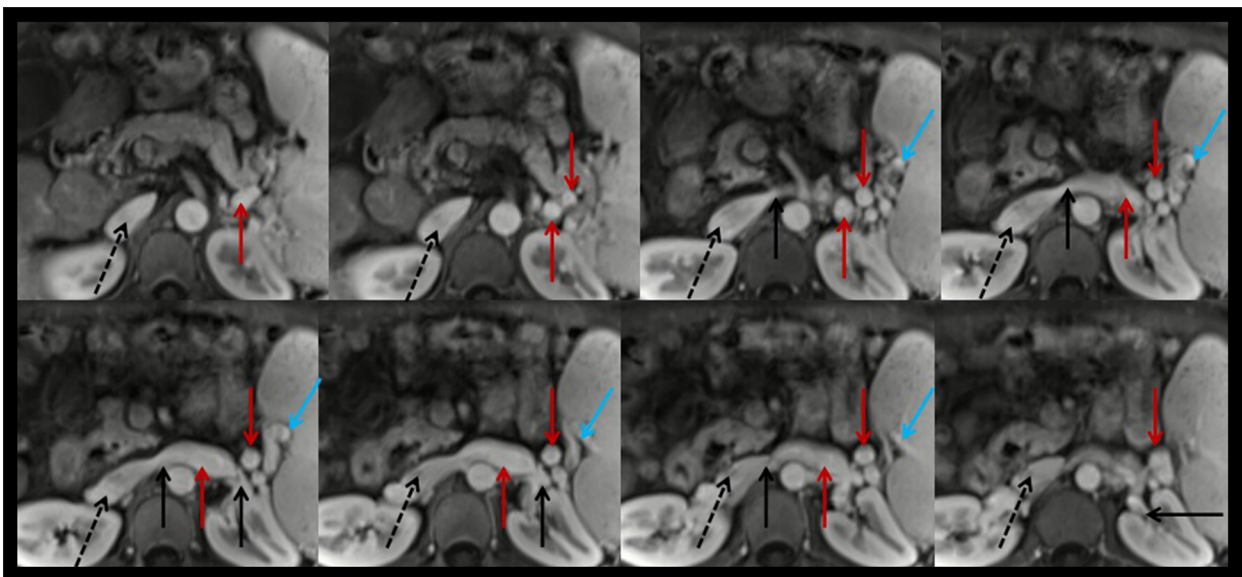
Axial contrast-enhanced MRI scans at the portal vein phase in a 44-year-old male patient with spontaneous splenorenal shunt (MQS). Black dashed arrows represent the inferior vena cava; black solid arrows represent the left renal vein; blue solid arrows represent the splenic vein; red solid arrows represent the communication between splenic vein and left renal vein.
